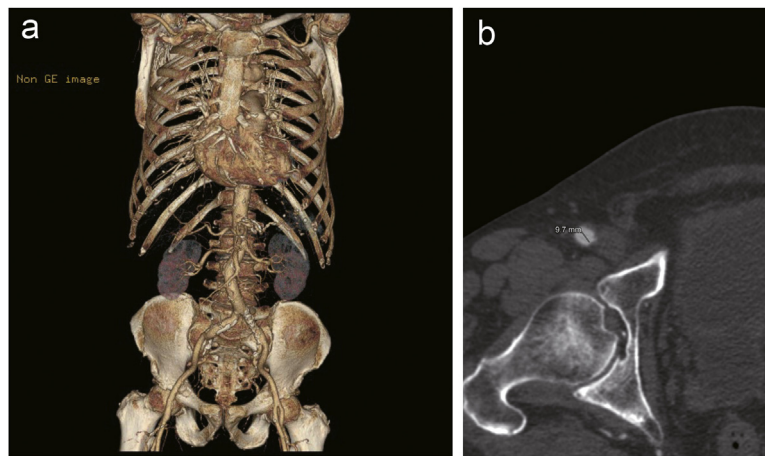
(a) and (b) Vascular assessment using multidetector computed tomography including the size, tortuosity, and calcification of the ilio-femoral arteries.
